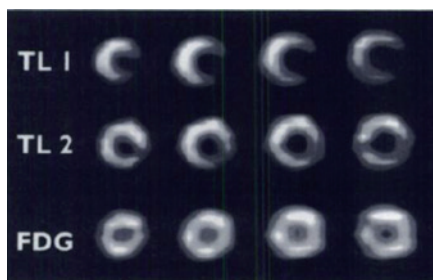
Corresponding series of ^{201}Tl rest-redistribution SPECT and FDG PET short-axis slices. The early ^{201}Tl slices (top) show a defect in the lateral wall and redistribution on late ^{201}Tl images (middle). FDG slices (bottom) show increased uptake in the lateral wall compared with early ^{201}Tl images. Lateral wall was akinetic on resting echocardiography and improved in function with revascularisation
